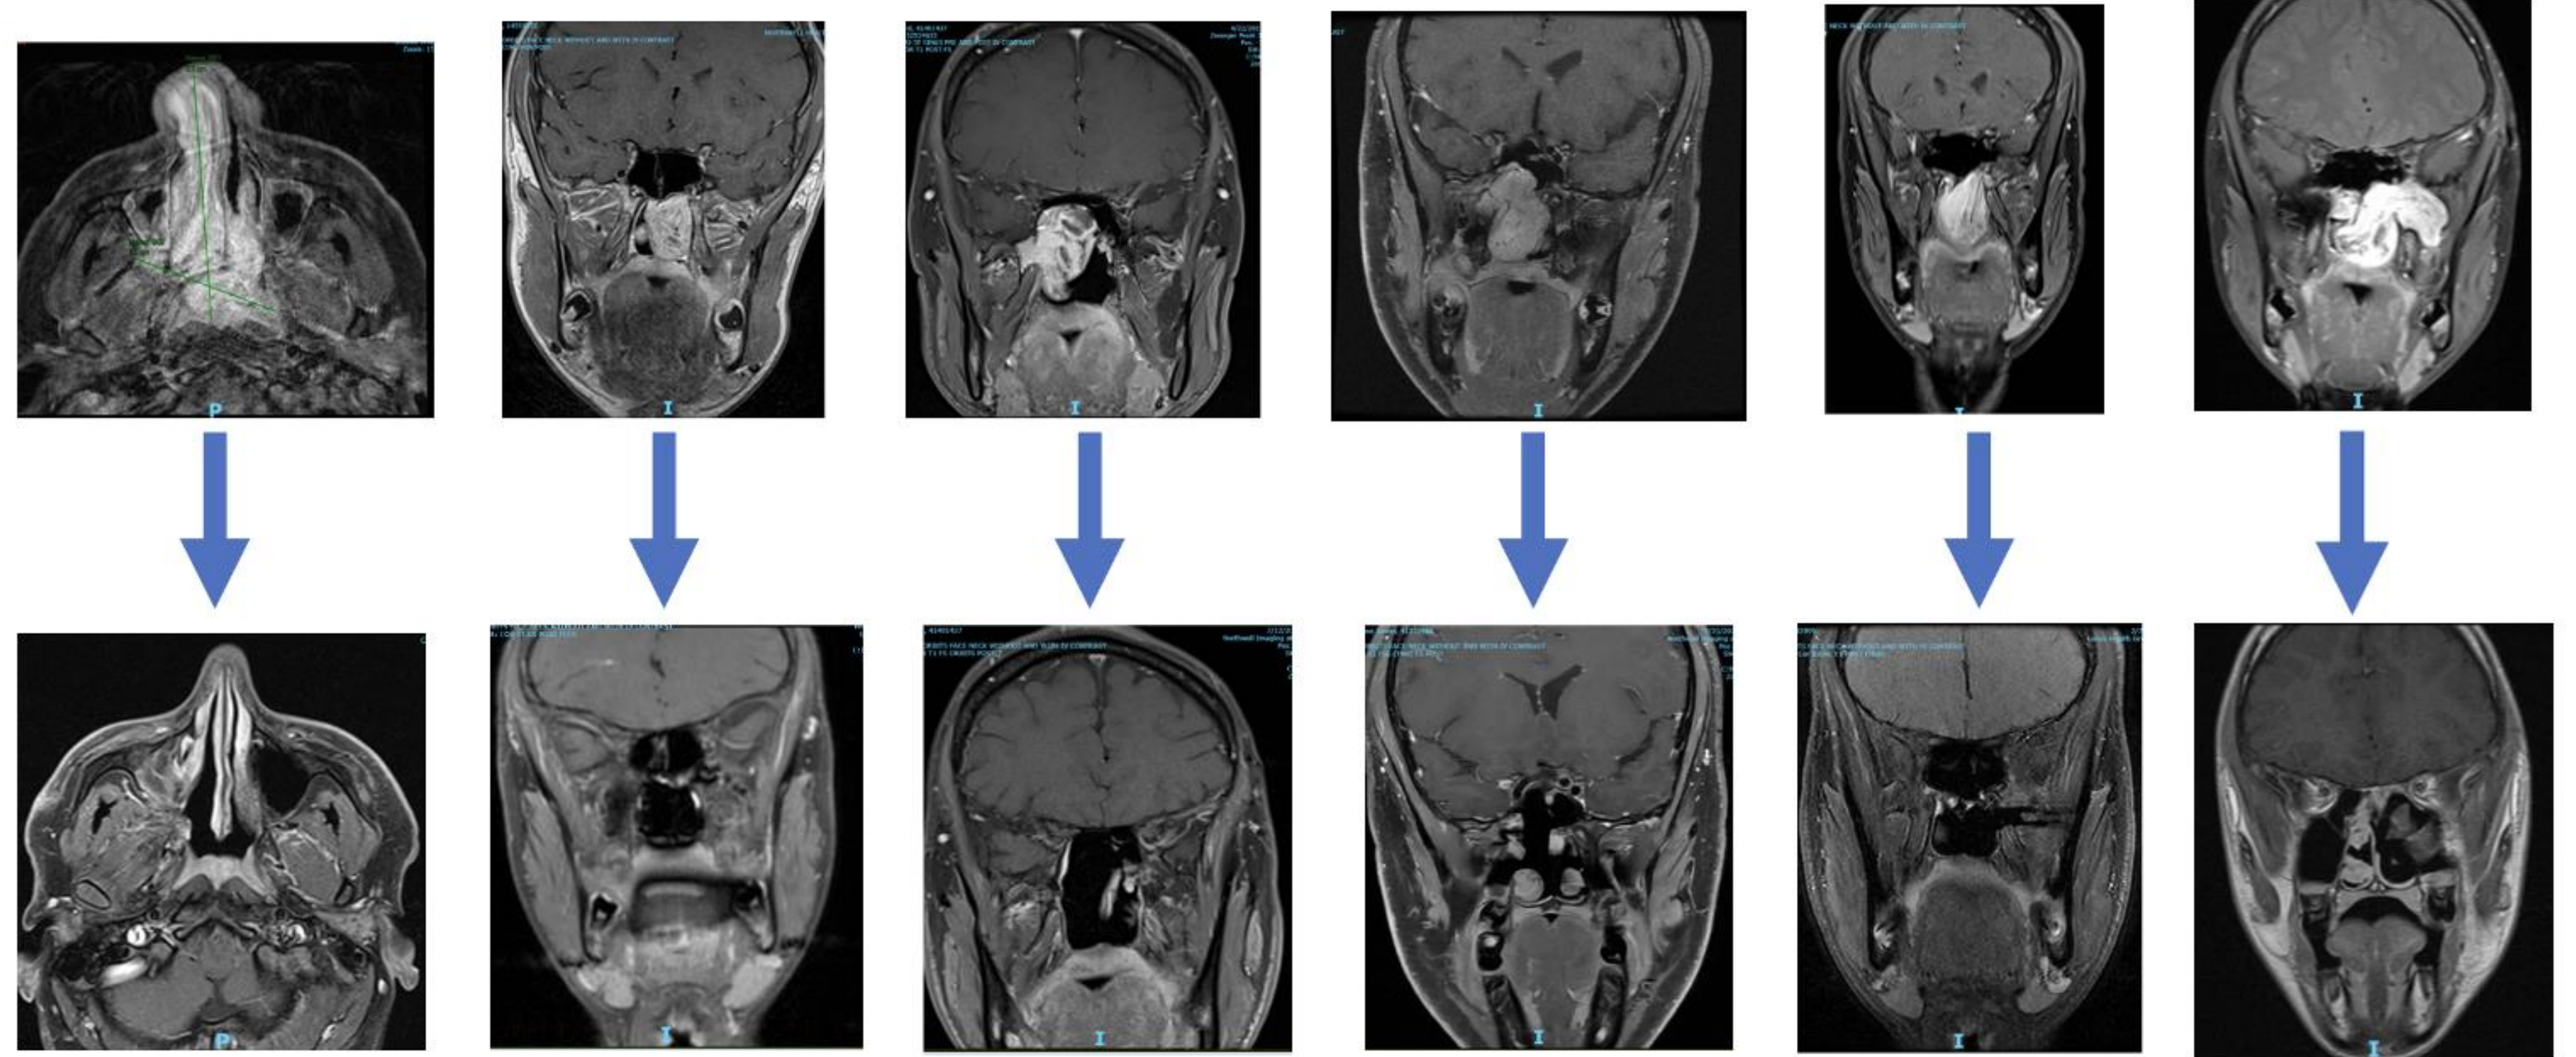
Pre and post operative MRI images
